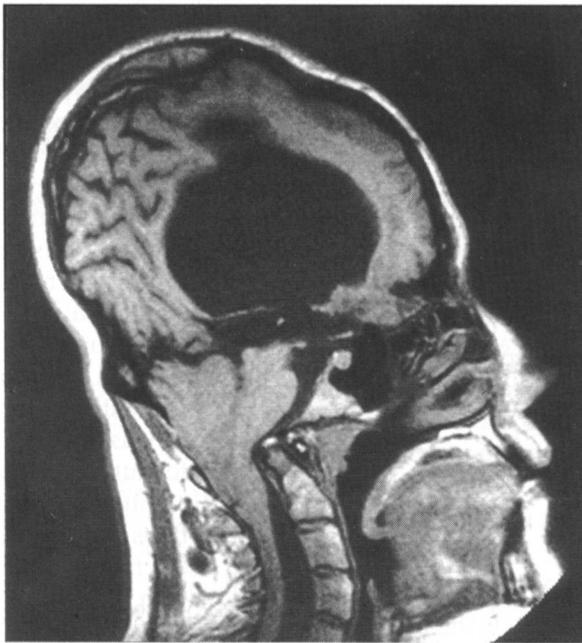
Infantile hindbrain herniation (Chiari type II) as seen on MRI scan. Note that there is hydrocephalus (H), all of the hindbrain is pushed downwards through the foramen magnum by the hydrocephalus. The cerebellum (CI) and medulla (M) are blended together and there is no fourth ventricle visible. This patient has reached adult life without treatment. A hydrocephalus shunt was successful.
